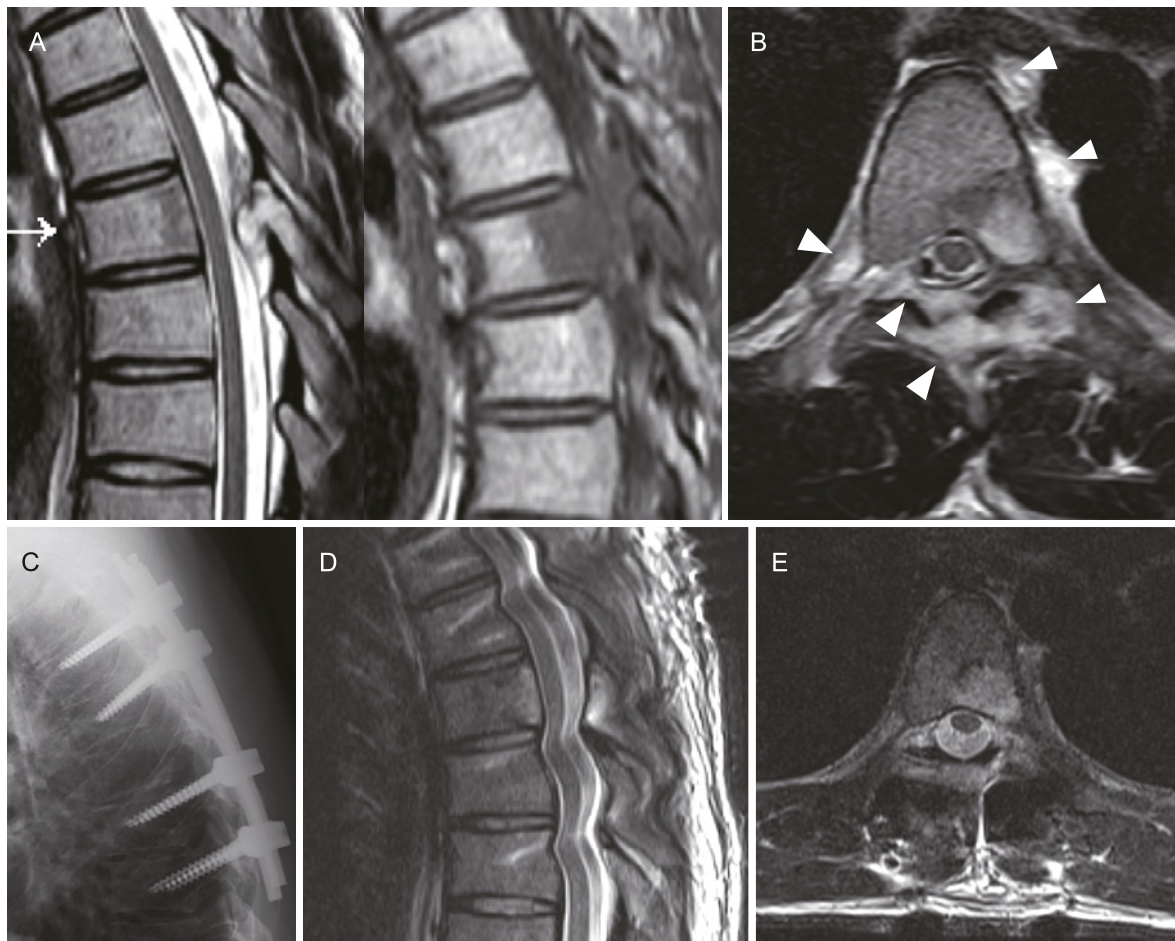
Imaging study of Case 1: A, T2-weighted (left) and T1-weighted (right) magnetic resonance imaging (MRI) displaying an abnormal lesion in the T6 vertebral body, lamina, and epidural space. B, T2-weighted axial MRI highlighting the abnormal lesion extending into the epidural and perivertebral spaces (indicated by white arrowheads). C, Lateral X-ray postfixation surgery, showing the surgical outcome. D and E, T2-weighted MRI scans taken 7 days postsurgery, revealing a significant reduction in the size of the epidural lesion.
